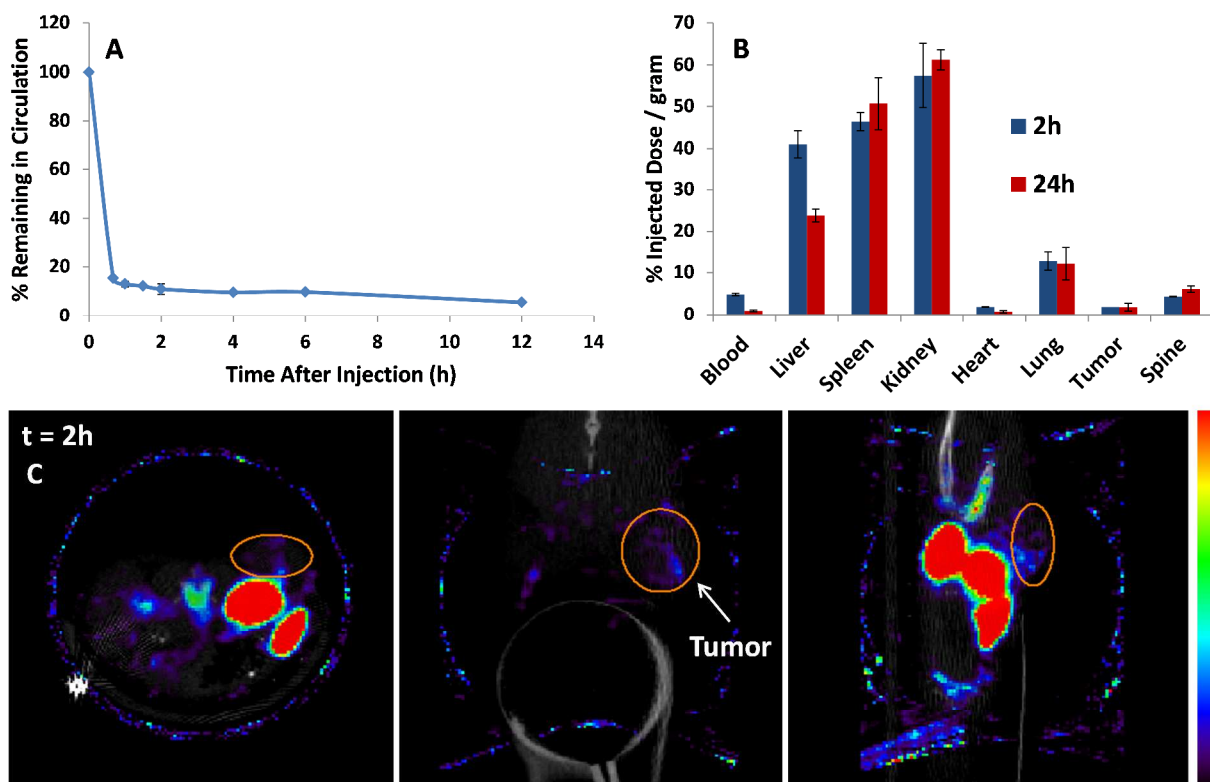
Biodistribution of IEP-PEG: A) Pharmacokinetics of  $^{111}\text{IEP-PEG}$ ; B) Organ biodistribution of  $^{111}\text{IEP-PEG}$  2h (n=2) and 24h (n=3) after treatment; C) SPECT/CT images of  $^{111}\text{IEP-PEG}$  2h after injection, from left to right: axial, coronal, and sagittal views.
